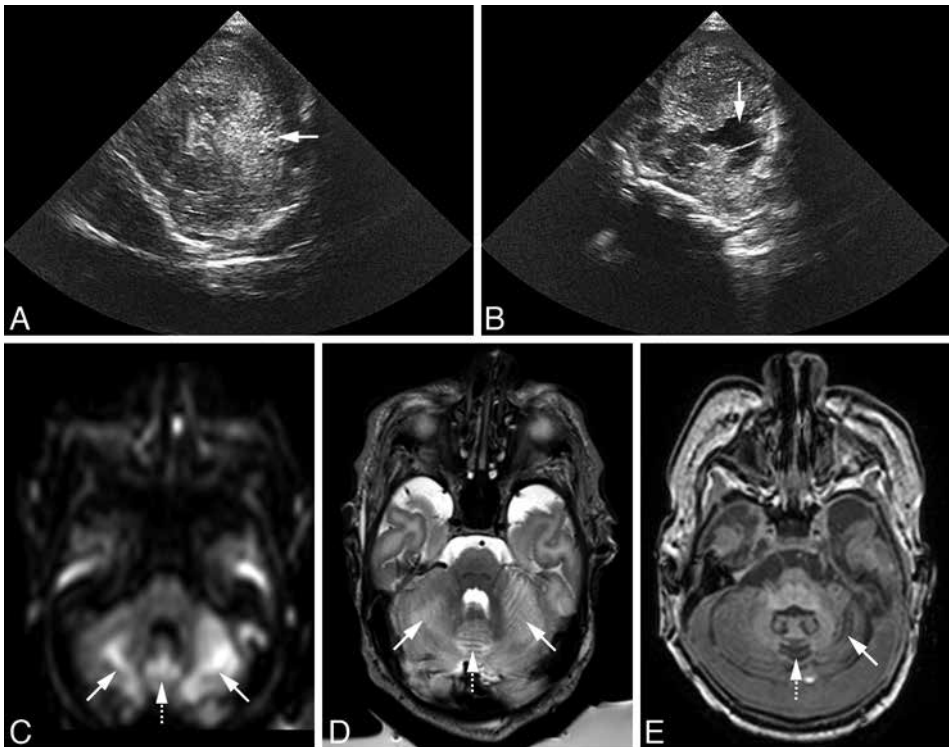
Axial ultrasound scan in full-term neonate (gestational age 40 weeks, Group B streptococcus meningitis) using the right MF as acoustic window. (A) On the 4th day of life, demonstrating abnormal echogenicity of cerebellar vermis and hemispheres (arrow). (B) Follow-up ultrasound scan on 11th day of life, demonstrating loss of parenchymal tissue of cerebellar vermis and left cerebellar hemisphere and loss of normal structure and anatomical landmarks (arrow).
